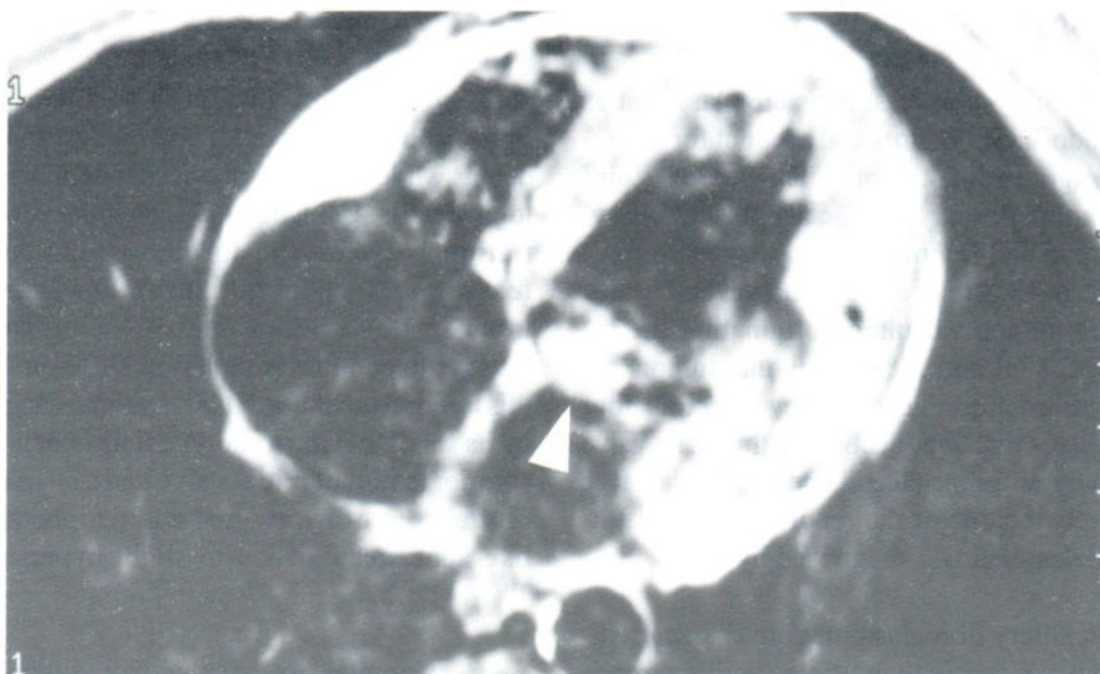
MRI SE T1W in axial plane revealed a small, well-defined mass of isosignal to slight hypersignal, attaching to the anterior leaflet of the mitral valve. Note the characteristic of the frond-like appearance of the tumor.
